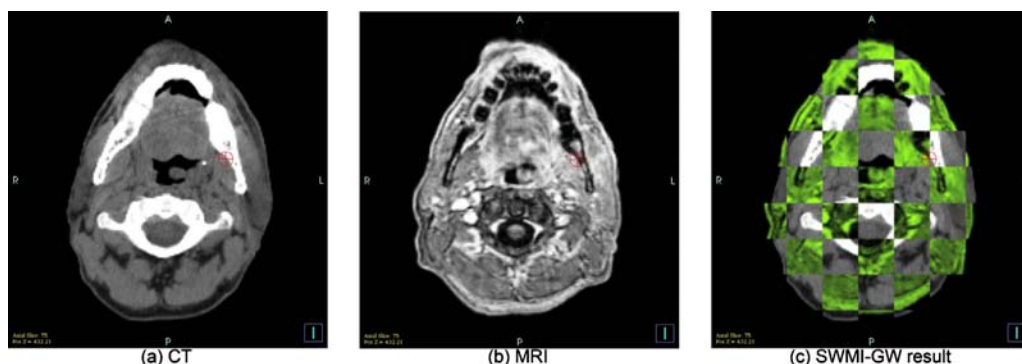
Image registration result between MRI and CT using SWMI-GW. The crosshair is the tumor isocenter. (a) CT, (b) MRI, and (c) the registration result of SWMI-GW.
